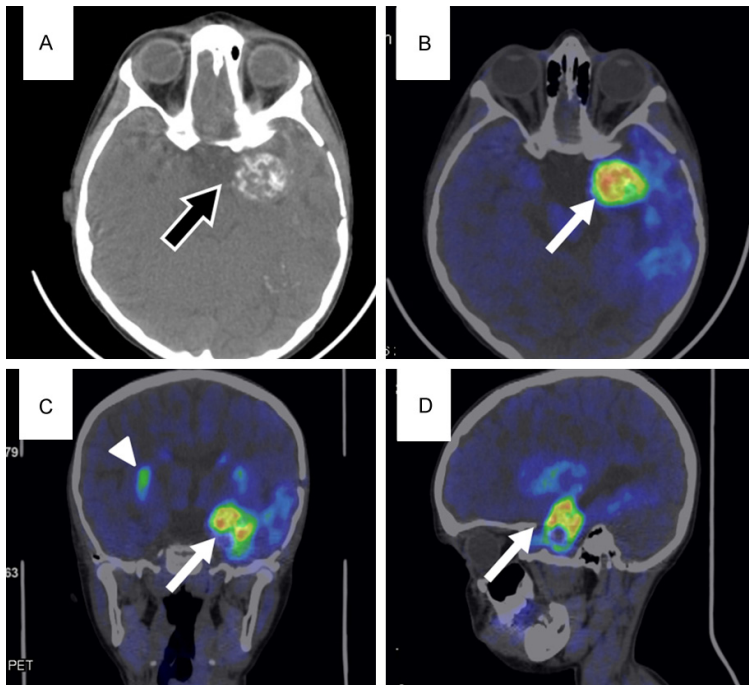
Anaplastic astrocytoma DH1 wildtype, grade III sec. WHO after radiotherapy. Axial CT (A) shows a calcified left temporal mass compressing the brainstem (black arrow). Axial (B), coronal (C), and sagittal (D) PET-CT images show increased ^{18}F -DOPA uptake at the same level (arrow). Visual score indicates higher uptake of the lesion compared to striatum uptake (arrowhead), referable to recurrence.
